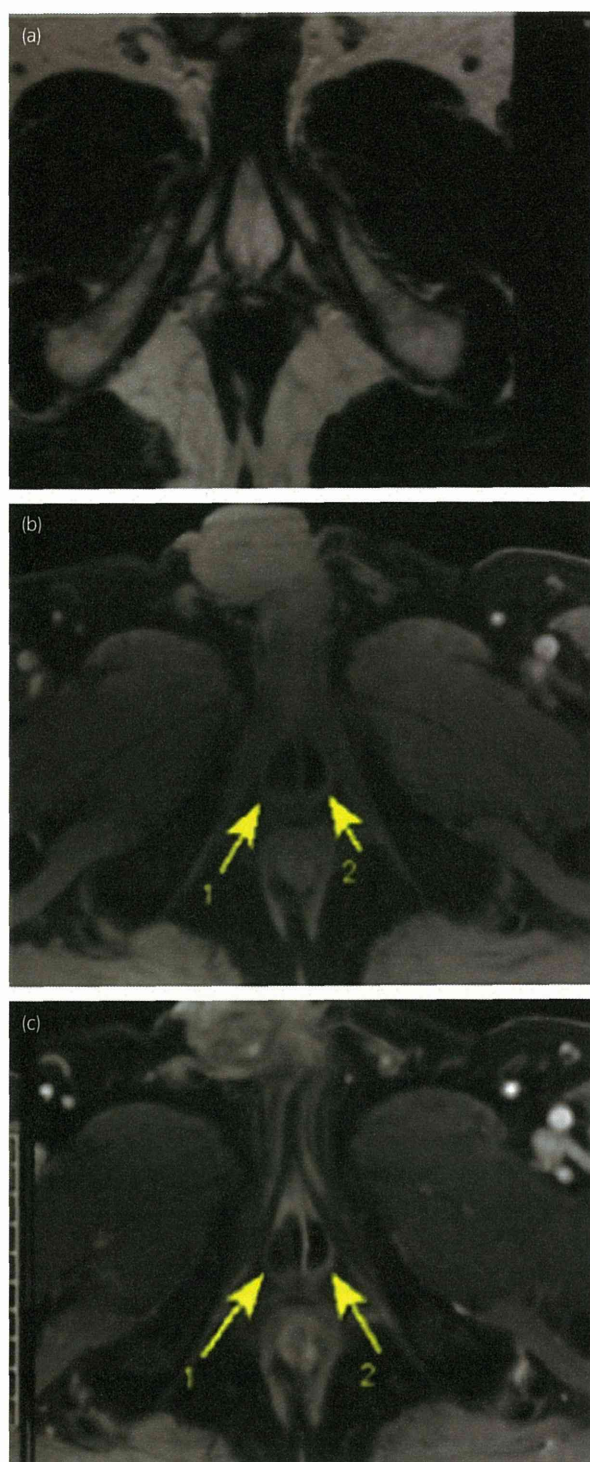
Magnetic resonance imaging around the urethra before and after the ADRC injection. The urethra in case 1 was visualized as a cross-section on magnetic resonance imaging. (a) Before injection, (b) 4 days after injection and (c) 12 weeks after injection. The arrows demonstrate the adipose tissue injected with ADRC. There was no change in the volume of injected adipose tissue between 4 days and 12 weeks after injection.
